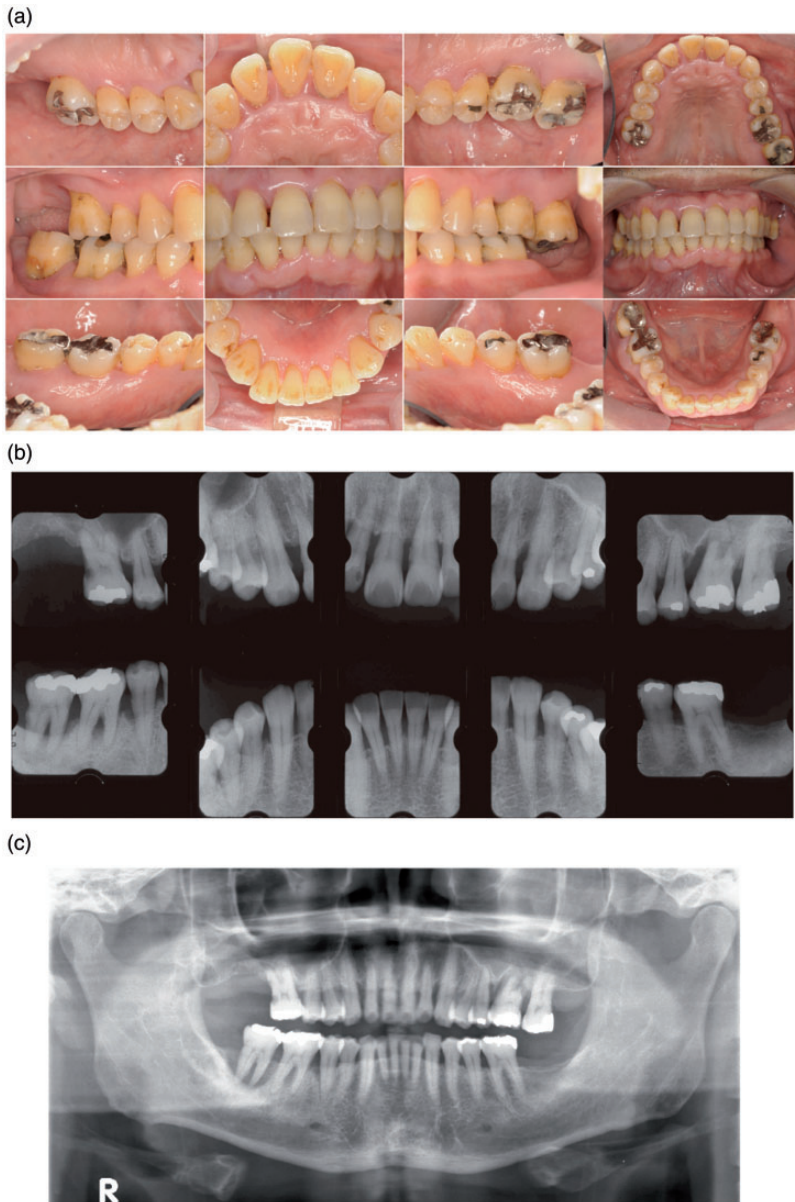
Oral view and radiographic images at baseline. (a) Intraoral images taken at the initial visit. Inflamed gingiva with swelling, redness, and purulent discharge are present due to accumulation of dental biofilm. (b) Radiographic images at the initial visit. Alveolar bone resorption suggests the existence of periodontal disease. (c) First panoramic radiograph in 2011 revealing a radiopacity in the left maxillary sinus.
